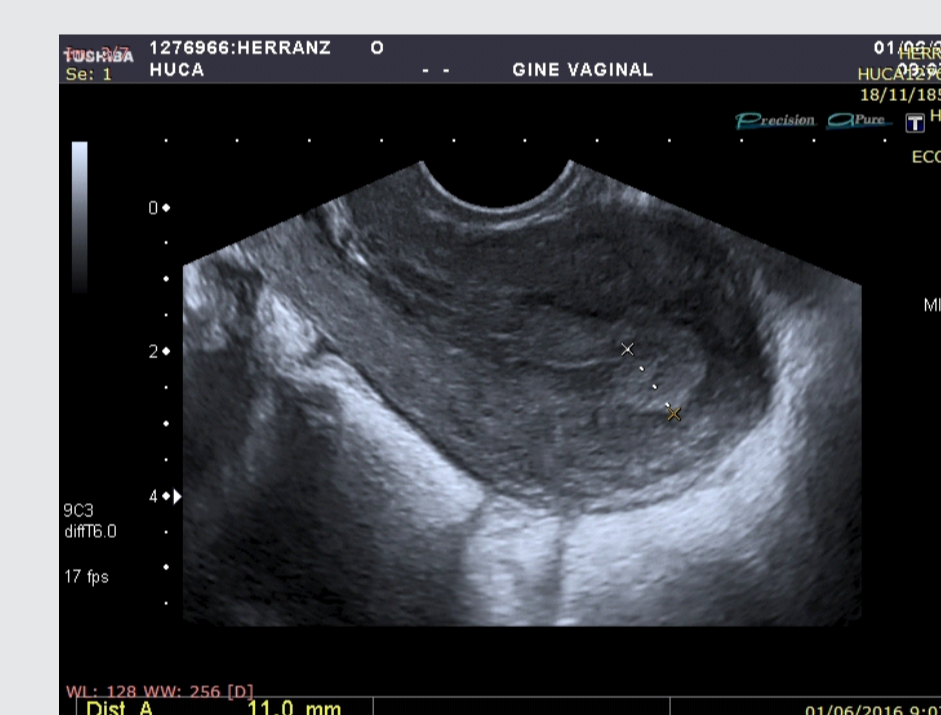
Basal ultrasound assessment. Diagnosis: 11 mm uterine polyp
